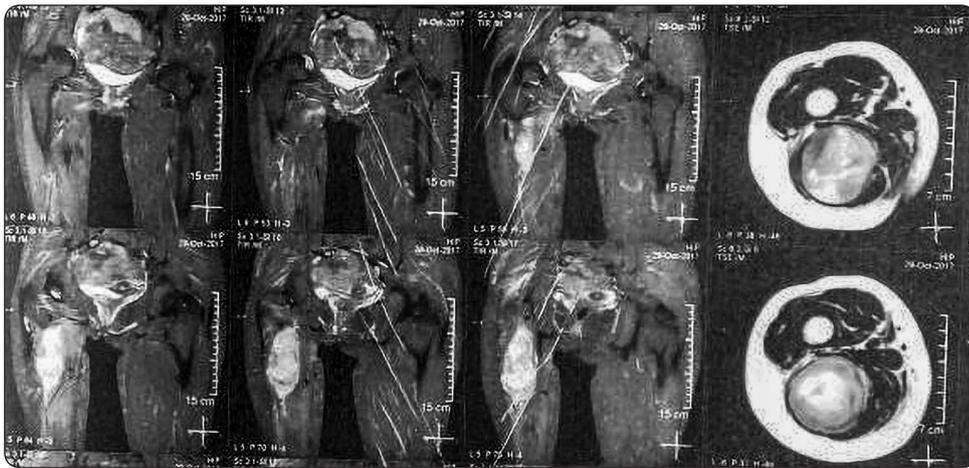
Magnetic Resonance Imaging (MRI) image of the posterior aspect of the right thigh: well-defined, homogeneous fusiform mass.
